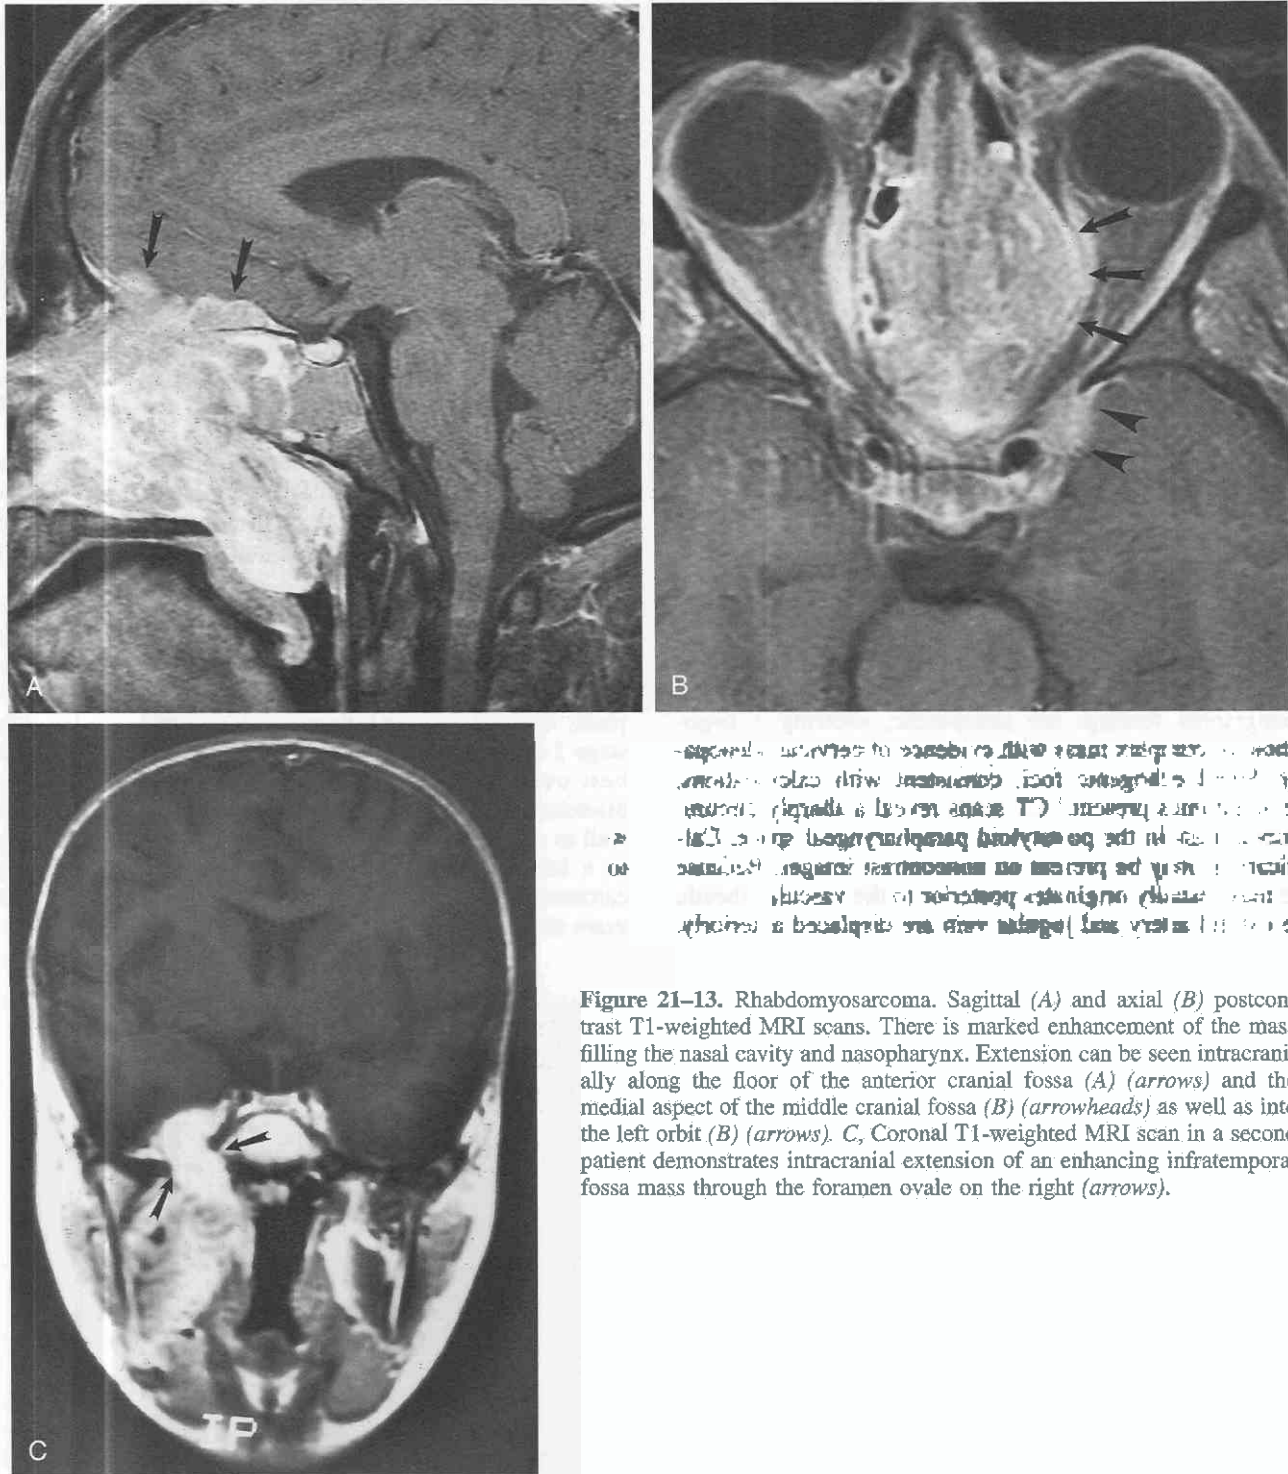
Rhabdomyosarcoma. Sagittal (A) and axial (B) postcontrast T1-weighted MRI scans. There is marked enhancement of the mass filling the nasal cavity and nasopharynx. Extension can be seen intracranially along the floor of the anterior cranial fossa (A) (arrows) and the medial aspect of the middle cranial fossa (B) (arrowheads) as well as into the left orbit (B) (arrows). C, Coronal T1-weighted MRI scan in a second patient demonstrates intracranial extension of an enhancing infratemporal fossa mass through the foramen ovale on the right (arrows).
